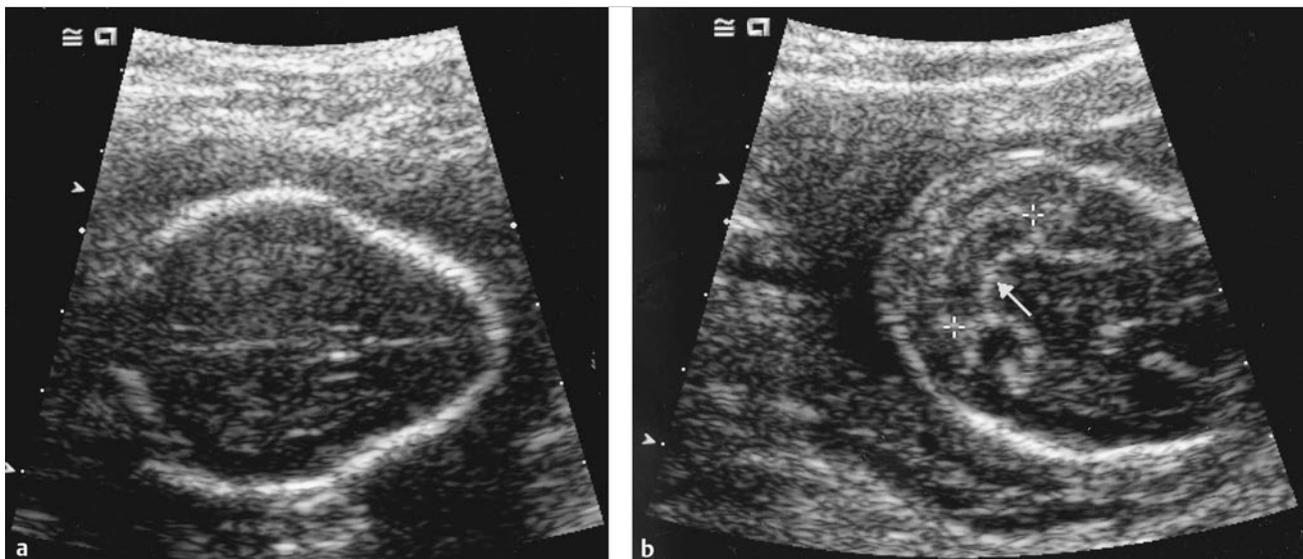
Prenatal cranial ultrasound signs associated with myelomeningocele. (a) Lemon sign (convex inward frontal bones). (b) Banana sign (Chiari malformation).
